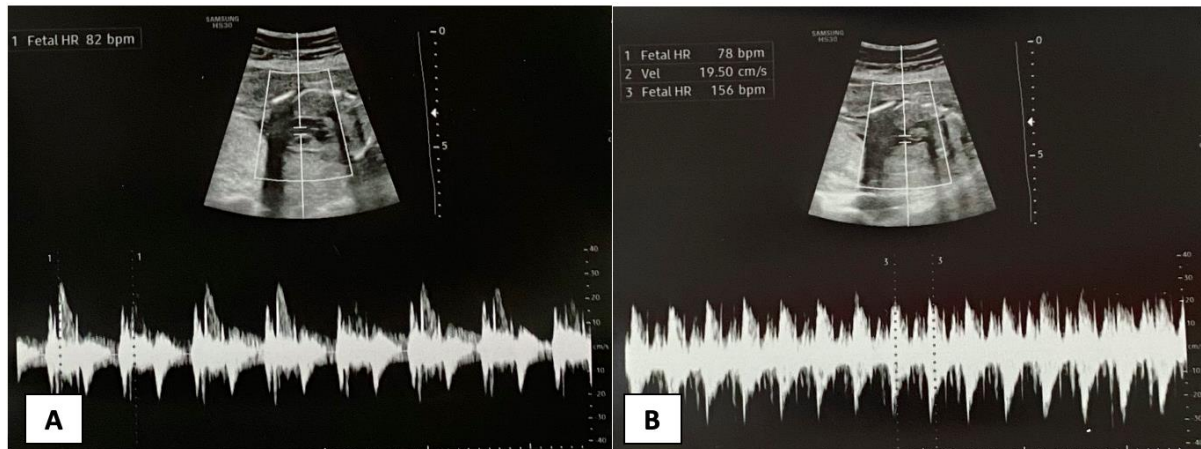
(A) Transabdominal ultrasound showed an incidental finding of fetal bradycardia with a fetal heart rate of 82 beats per minute. (B) Transabdominal ultrasound showed a repeated fetal heart rate of 72 beats per minute, and after 2 minutes of observation, the fetal heart rate reverted to normal with 156 beats per minute.
